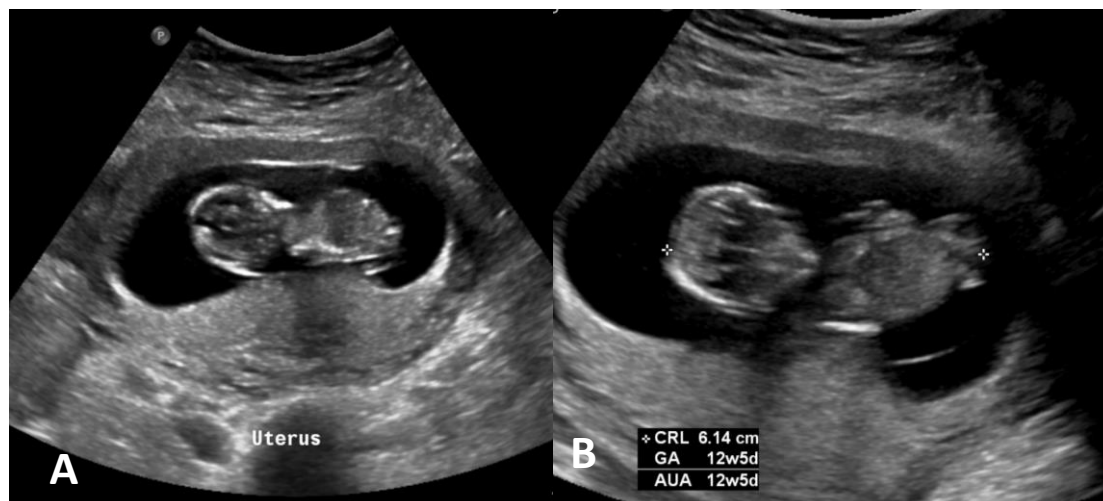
A and B. Ultrasonography showing gravid uterus with singleton. Fetal heart was present.
